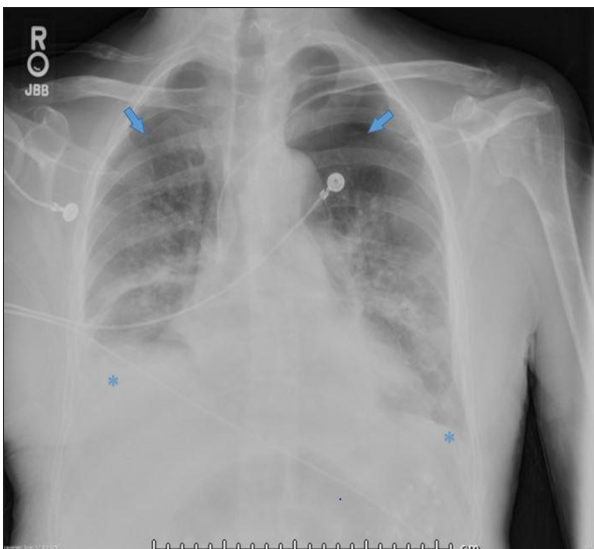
Chest x-ray after feeding tube was removed, revealing bilateral apical pneumothorax left greater than right (see arrows). Also shown in the x-ray are bilateral pleural effusions right greater than left (asterisks).
